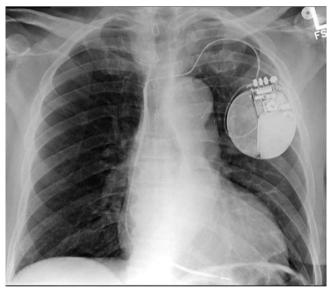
Chest X-ray on Day 3 after extubation.
